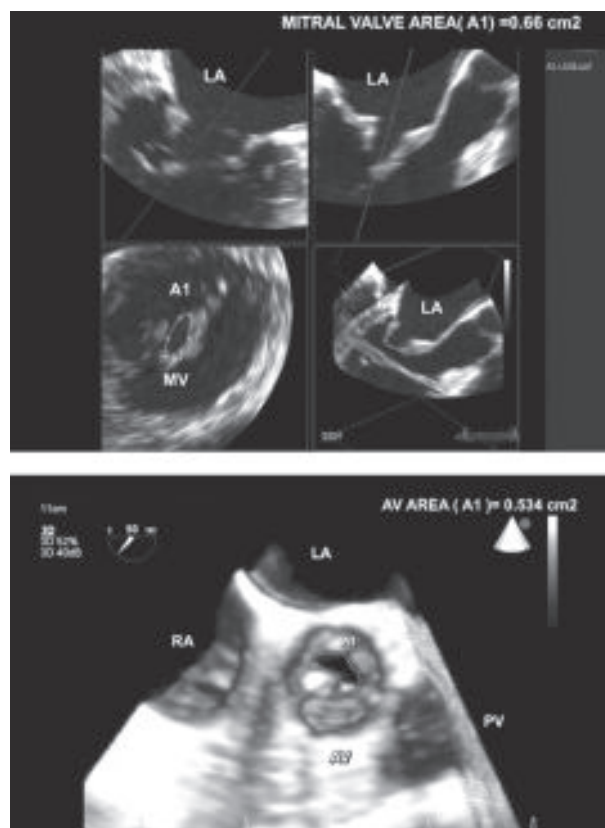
Three- dimensional transesophageal echocardiograms. MVA of 0.66 cm² consistent with severe mitral stenosis. AV area of 0.534 cm² indicative of severe aortic stenosis.
